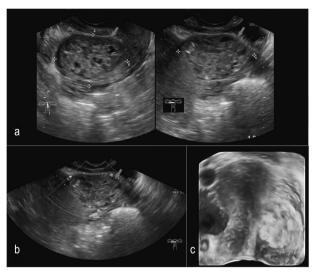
BUS prior to chemotherapy in case one. a) A honeycomb-like inhomogeneous echo pattern $(5.1\times3.9\times3.4$ cm, red arrow) is detected in the myometrium of the left wall of the isthmus, extending to the serosal layer. b) Color Doppler ultrasound shows abundant blood flow inside the nidus (RI = 0.35). c) Three-dimensional ultrasound shows the nidus bulging outward.
